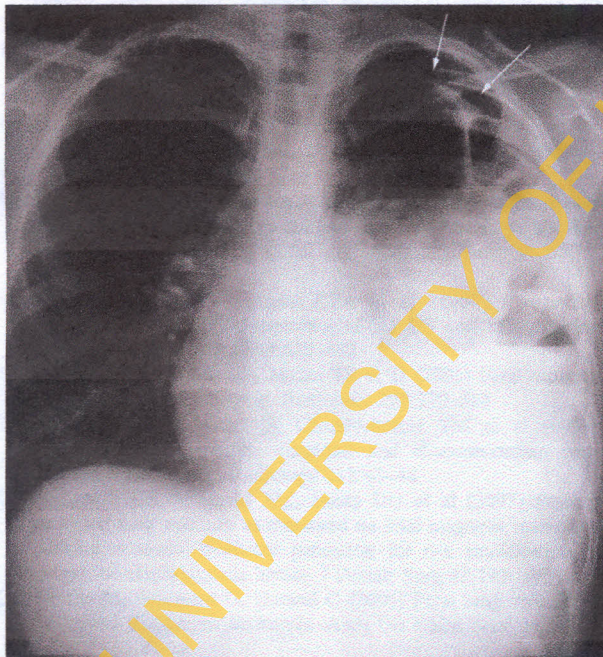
A 14-year-old girl with late presentation of a Bochdalek hernia, presenting with fever and initial periumbilical pain that migrated to the left shoulder. Chest radiograph shows bowel in the left hemithorax and a pneumothorax (arrows). At surgery, a Bochdalek hernia and perforated appendix were identified in the left hemithorax
